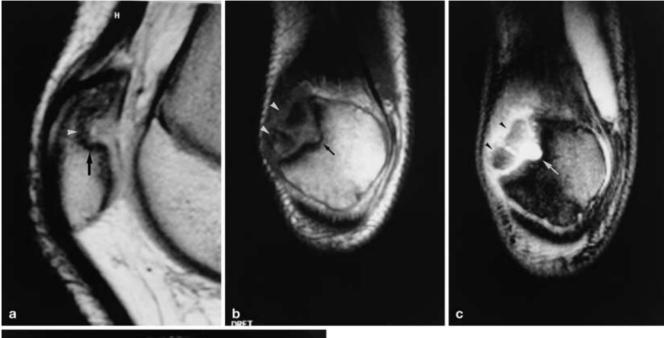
Unfused bony fragments are also seen (arrowhead). a On MR sagittal turbo spin-echo proton-density weighted imaging the dorsal defect shows a well-marginated hypointense rim (arrow), becoming ill-defined on its deepest aspect (arrowhead). Focal mild hyperintensity is seen inside the defect. b Coronal T1-weighted SE image and c gradient-echo T2-weighted image clearly show the incomplete well-marginated borders of the dorsal defect (arrows), and the fragmented appearance of the supero-lateral pole (arrowheads). d Axial 3D gradient-echo image depicts to best advantage the chondral thickening covering the unfused small bony fragment (asterisk). A depression and focal interruption of the thickened cartilage abutting the cortical defect is also seen (arrow)
